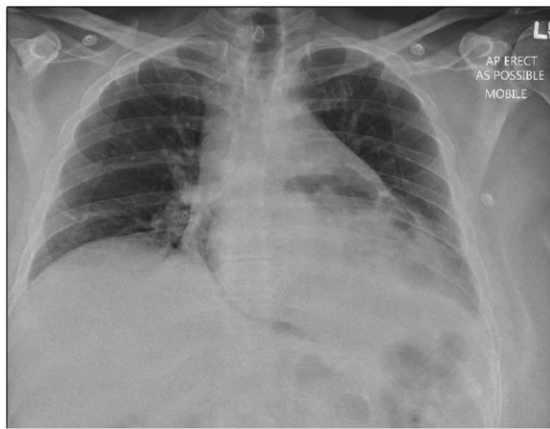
Chest X-ray demonstrating pneumopericardium and enlargement of the cardiac silhouette.
